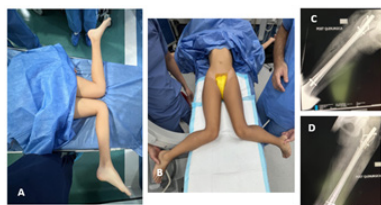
Preoperative physical examination. A. Prone position. B. Supine position. Postoperative radiographs. C. Right femur radiograph. D. Left femur radiograph.
